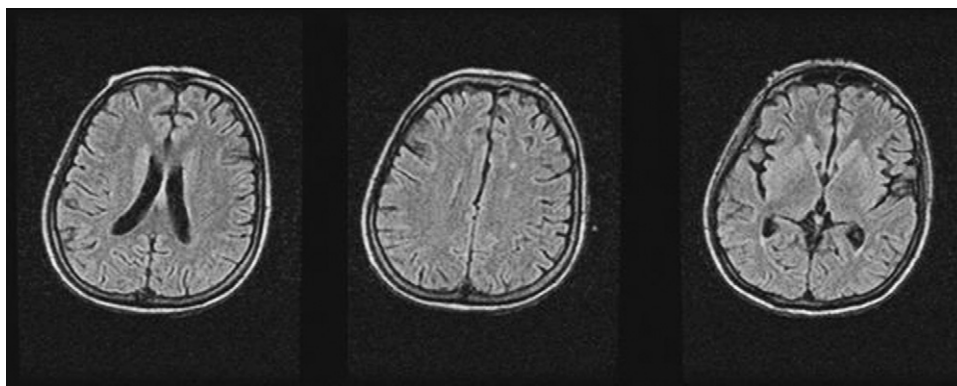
MRI showing features of vasculitis of left fronto temporal region.
